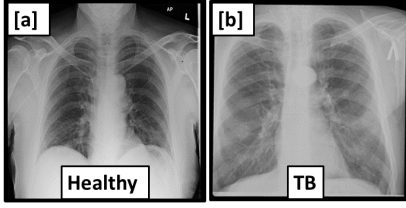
The samples of chest X-ray images used in this work.
